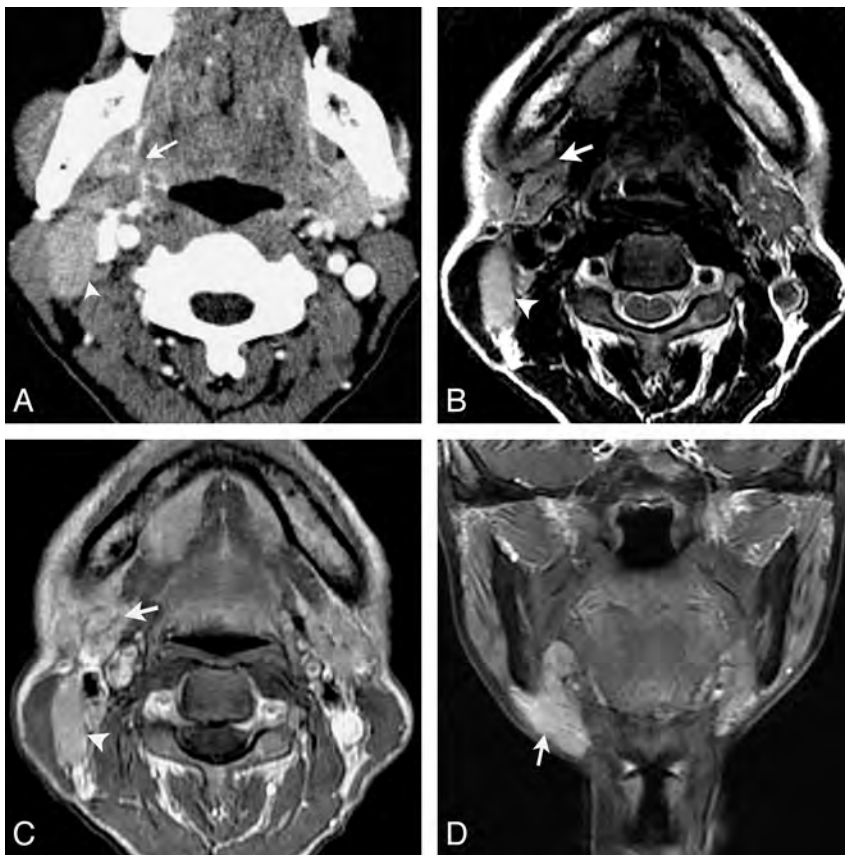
LEC of the right submandibular gland in a 53-year-old woman with a painless mass in the right neck for 1 year. Axial contrast-enhanced CT (A) shows an ill-defined mass in the right submandibular gland with heterogeneous moderate enhancement (arrow). An enlarged lymph node in level IIa is also noted and shows a homogeneous enhancement (arrowhead). Axial T2-weighted image (B) shows a heterogeneous slight hyperintensity mass with curvilinear and linear hypointensity within it (arrow) and an enlarged lymph node in level IIa (arrowhead). Gadolinium-enhanced axial T1-weighted image (C) and coronal T1-weighted image with fat saturation (D) show the mass with a heterogeneous enhancement with hypo-enhanced strands within it. An enlarged region of the lymph node in level IIa is also noted and shows homogeneous enhancement (arrowhead).
